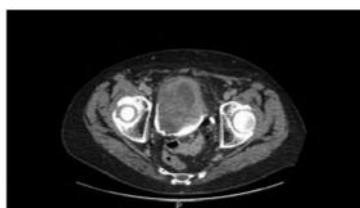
Abdominal computed tomography of pleomorphic sarcoma; axial scan.
